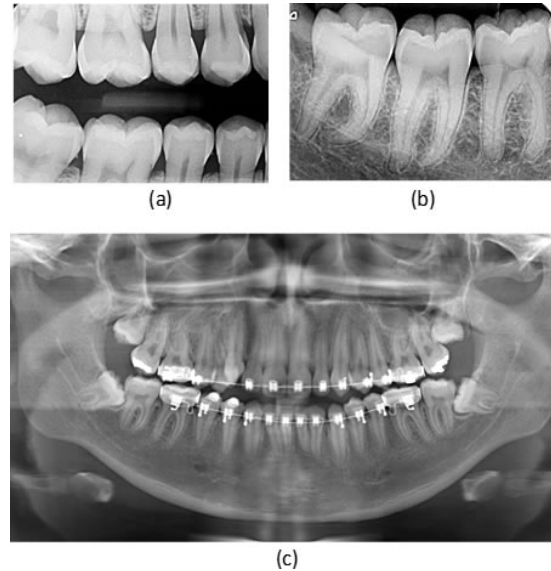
Types of X-ray images: (a) Bitewing X-ray; (b) Periapical X-ray; (c) Panoramic X-ray.
